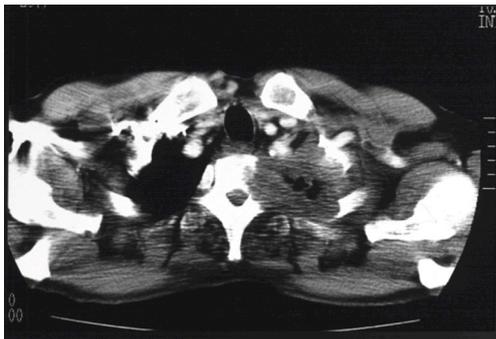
Chest computed tomography scan showing an apical chest wall tumor with spinal involvement.
